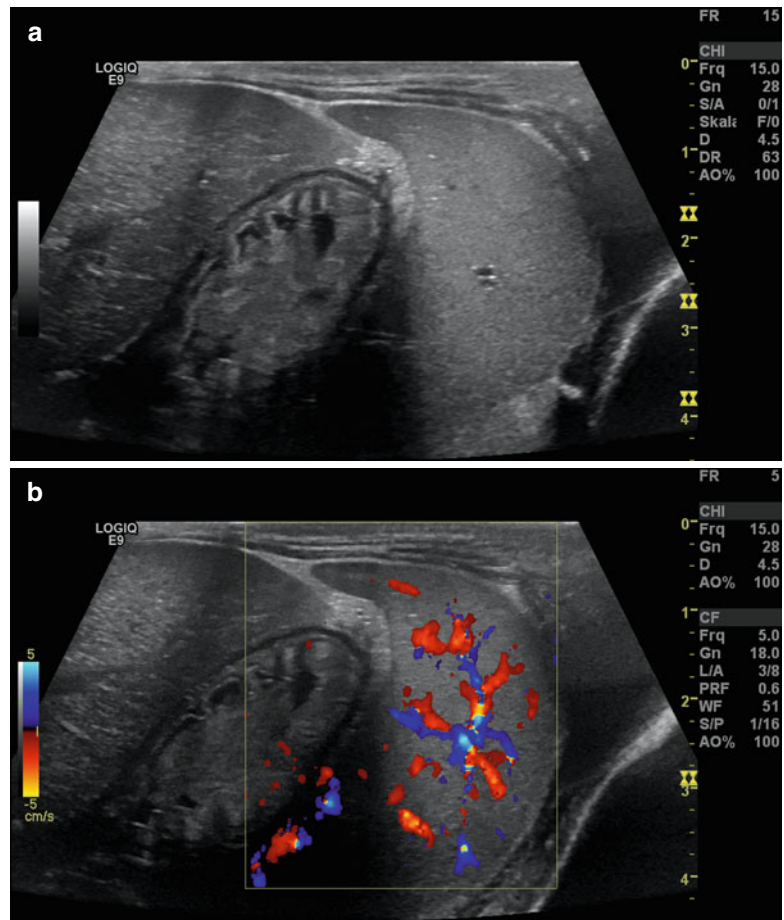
Newborn with hepatosplenomegaly due to myelodysplastic syndrome. In newborns and infants and for the detection of smaller focal lesions, high-resolution linear transducers up to 17 MHz are optimal for visualisation of the parenchyma. (a) “Kissing phenomenon” of the liver and spleen. The stomach is in between. B-mode image. Transverse section through the spleen. (b) Colour Doppler image of the splenic perfusion. Transverse section through the spleen
